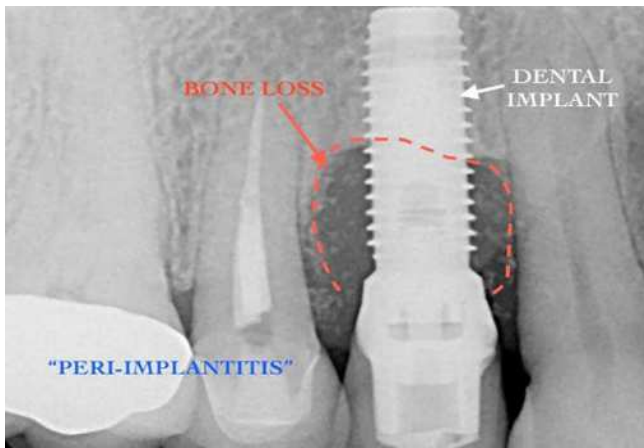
Xray of defective implant and Root Canal Treated Tooth. Image retrieved from <https://portlandperioimplantcenter.com/implant-disease-and-therapy/>
